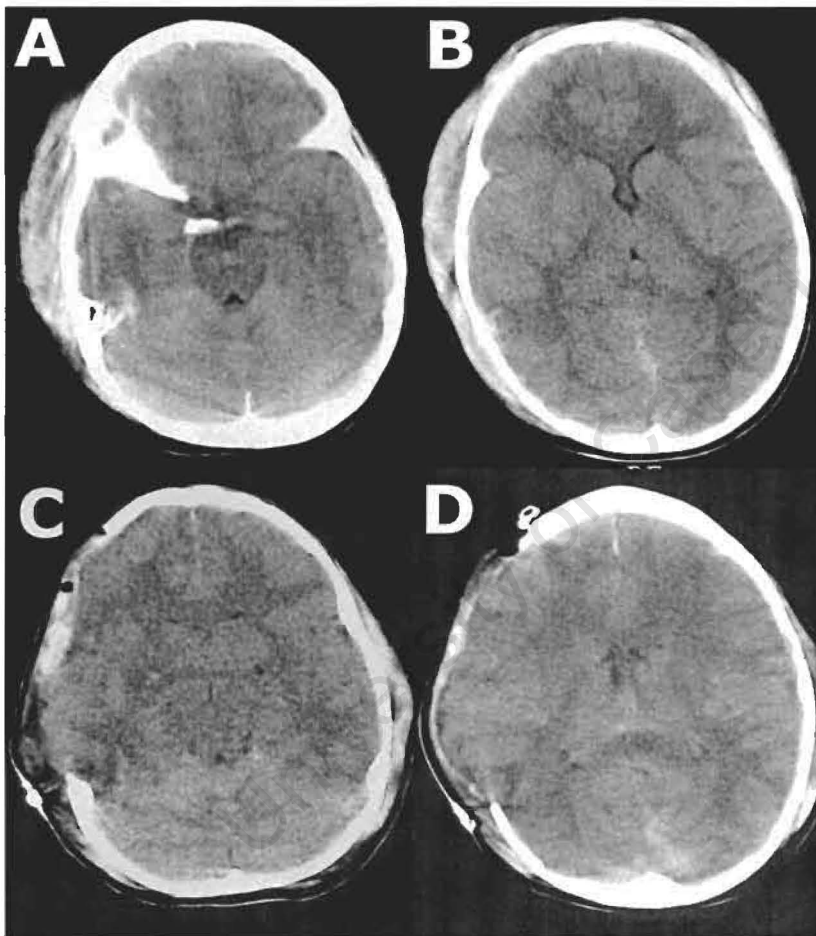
a+b, CT head of the patient before surgery; c+d, CT head of the patient after DCH.
